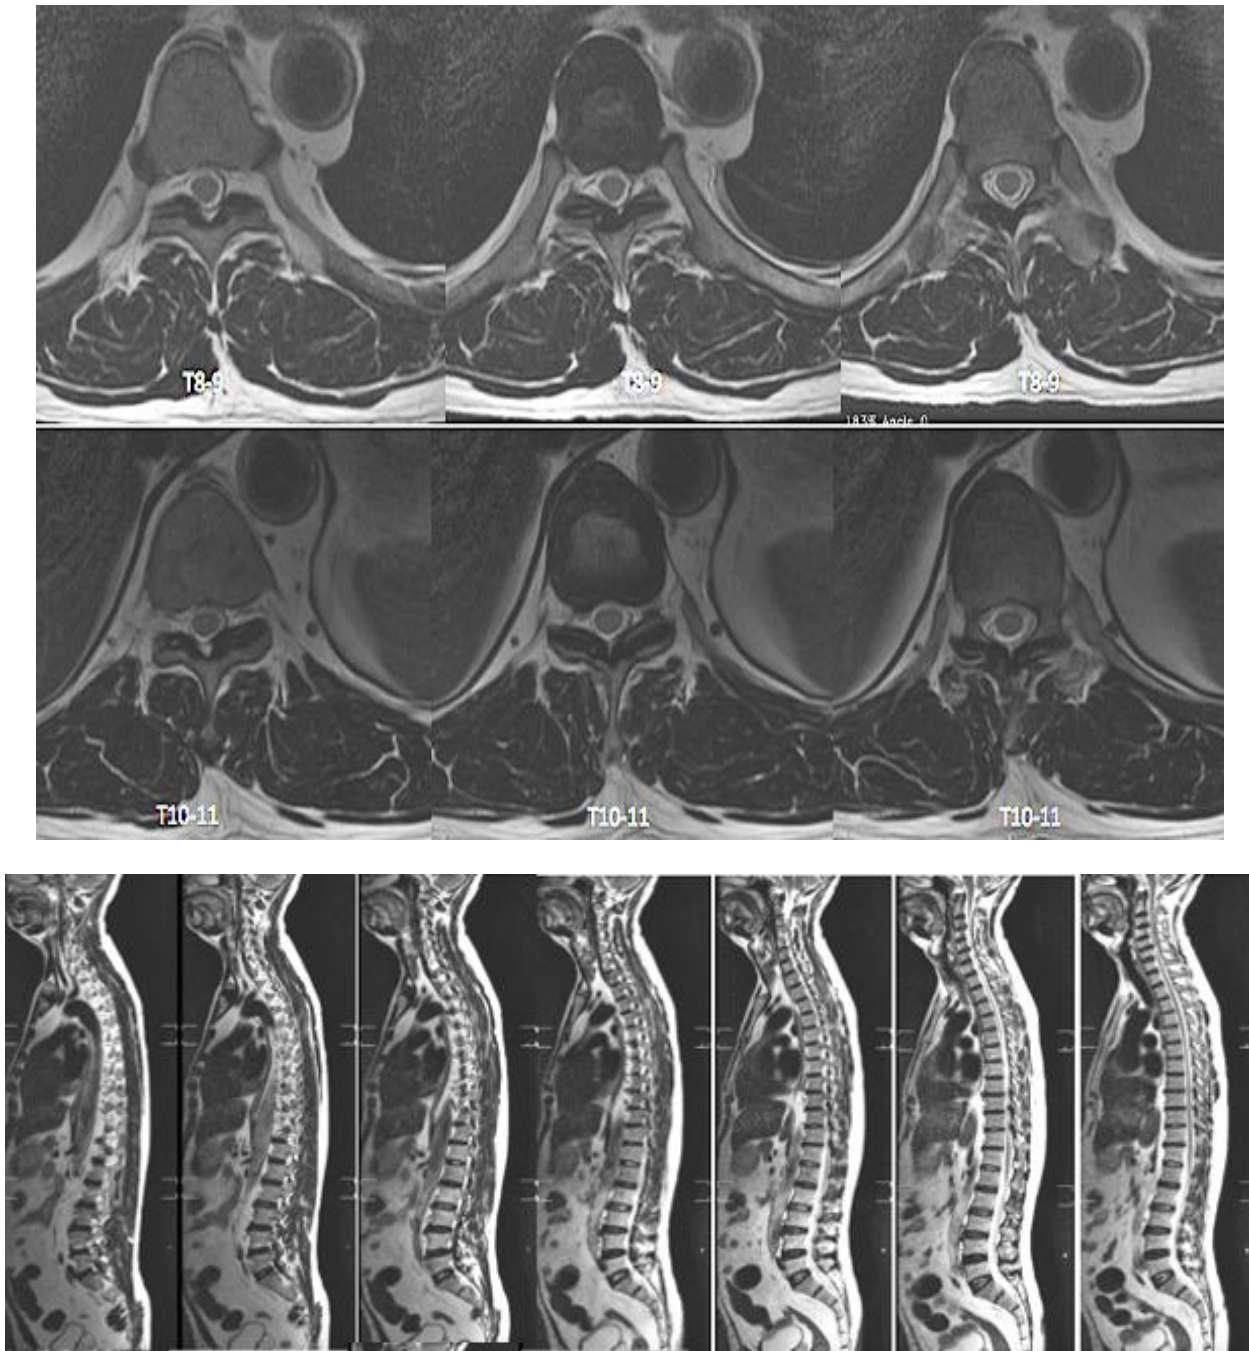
MRI Thoracolumbal (A) Non Contrast T2W Axial View, (B) Non contrast T1W axial view (C) Thoracol non contrast T1W Axial View (D) Thoracal non contrast T2W Axial view (E) Whole Spine Non contrast T2W sagittal New
